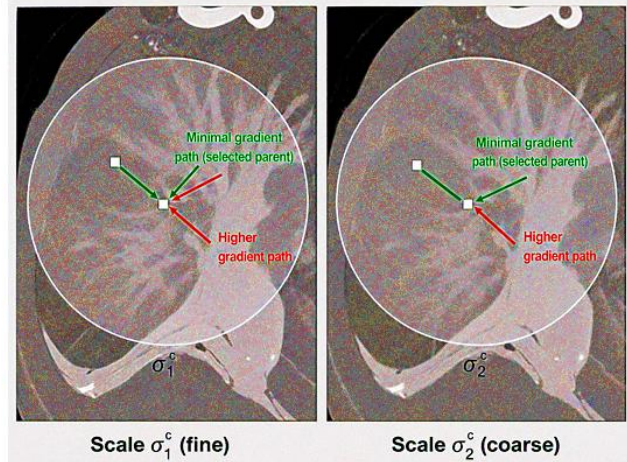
Search window for associating the child pixels with parent nodes in lung CT.
